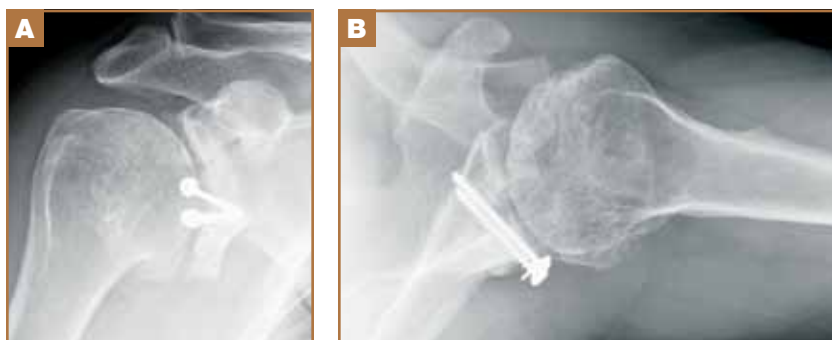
Radiographs in AP (A) and axillary (B) view at 24 months follow-up: concentric glenohumeral joint alignment, no signs of graft osteolysis, moderate glenohumeral osteoarthritis.
